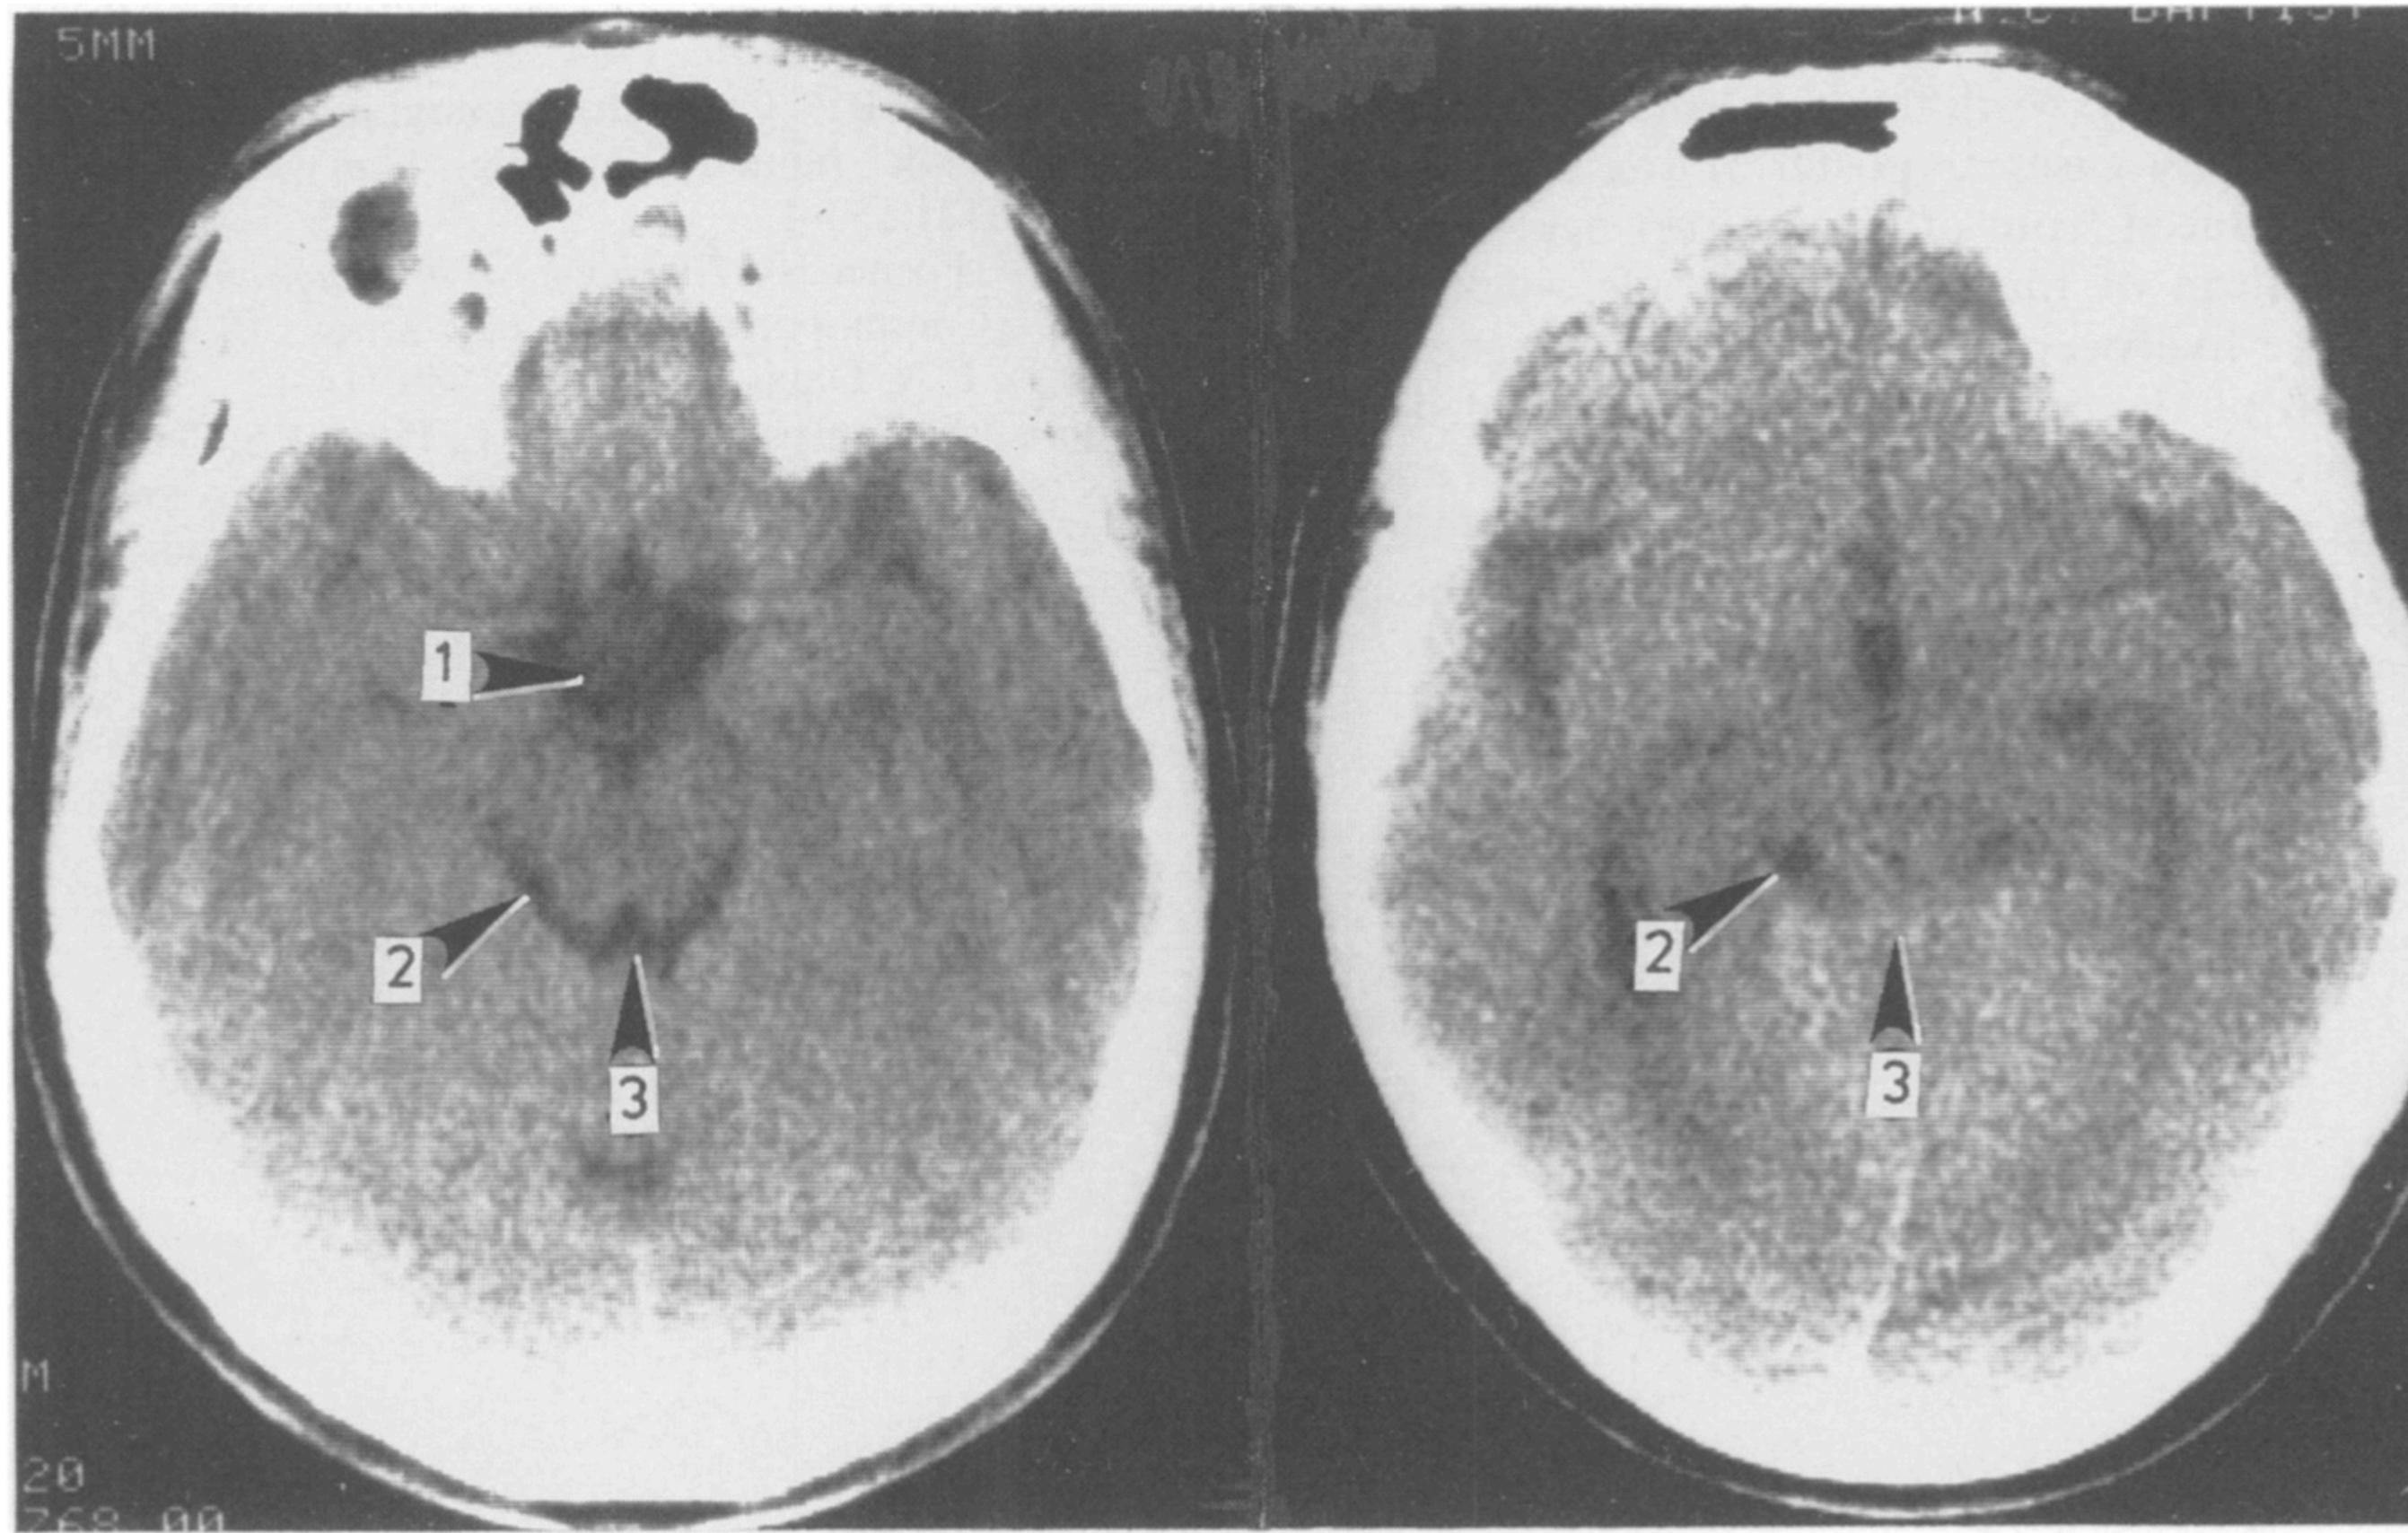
(left) Normal uninjected CT scan demonstrating the basilar cisterns (1 = suprasellar cistern, 2 = ambient cistern, 3 = quadrigeminal plate cistern), and (right) an example of upward transtentorial herniation with obliteration of the quadrigeminal plate cistern (3) and sparing of the ambient cistern (2).
